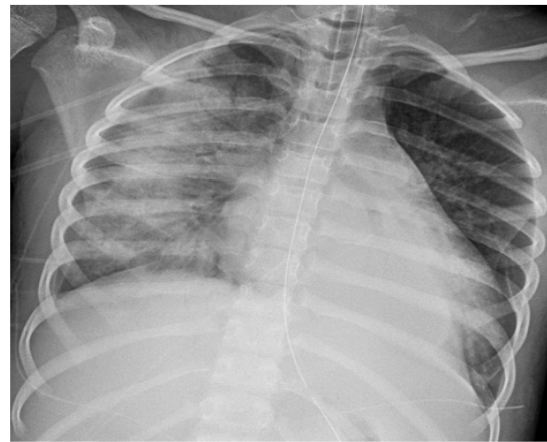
8-year-old female, who presented MIS-C associated with COVID-19, with fever, sore throat, vomiting, diarrhea, abdominal pain, back pain and fatigue. The patient ultimately progressed to develop hypoxic respiratory failure, hypotension, myocarditis, and acute kidney injury. Frontal chest radiograph shows an ARDS pattern with asymmetric, right greater than left, hazy opacities, and dense consolidative opacity in the left lung base, and cardiomegaly.¹⁵⁷ Printed with Permission.
